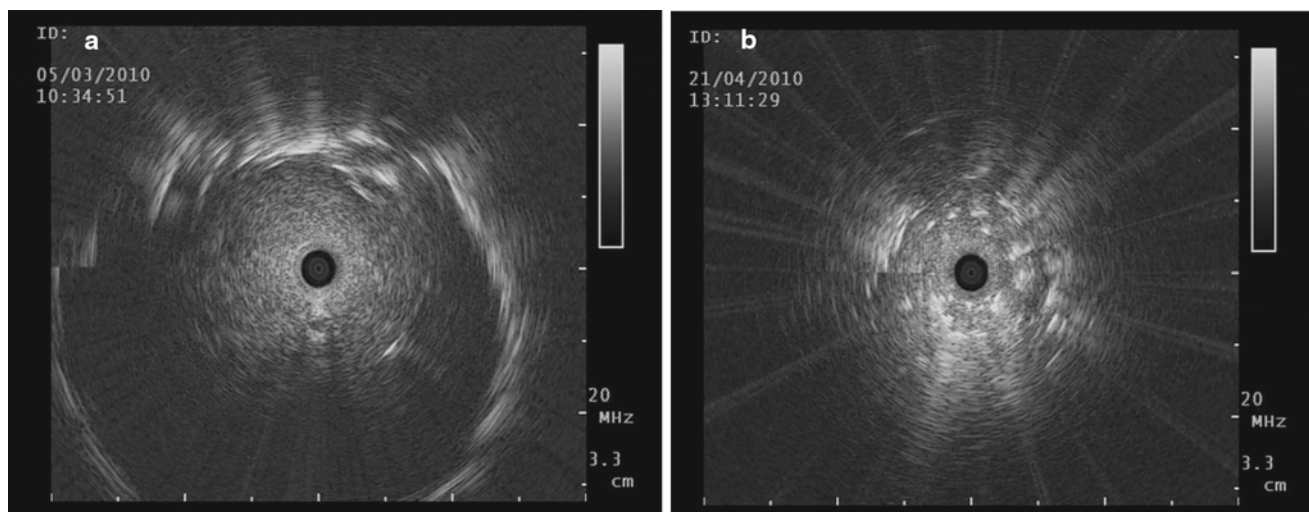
(a) Typical ultrasound image of a malignant solid tumour with clear borders. No air bronchogram is seen, which is a distinguishing sign for inflammatory disease or atelectasis; (b) white spots are visible centrally and the borders of the lesion are blurred in this benign lesion
